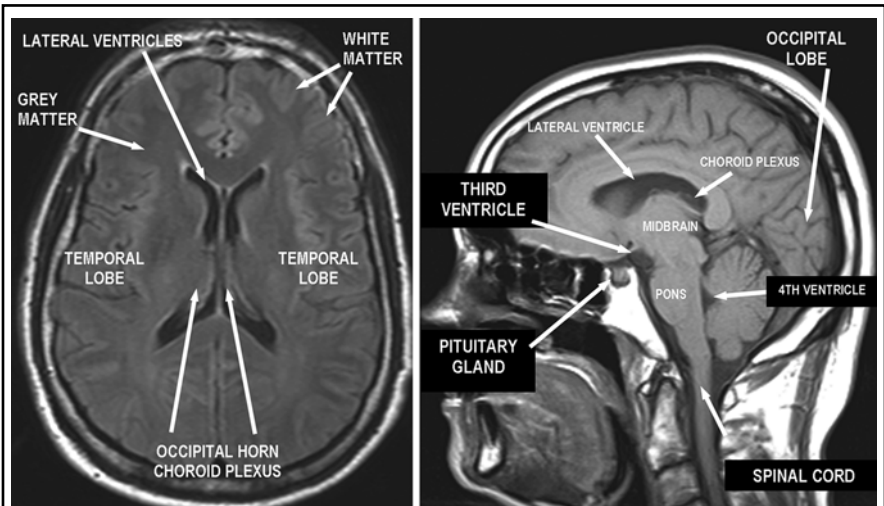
BASIC MRI NEUROANATOMY
